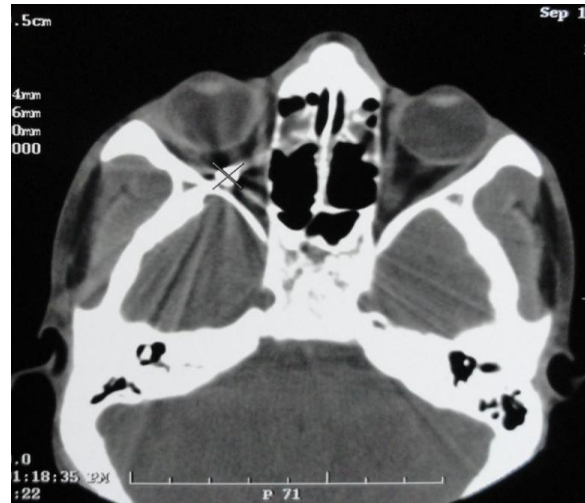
Axial CT scan of a patient with Open Globe Type D injury.
